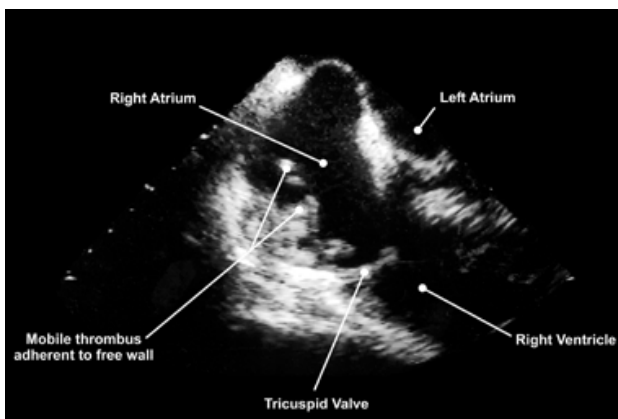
Trans*-oesophageal echocardiogram of right atrial thrombi.
